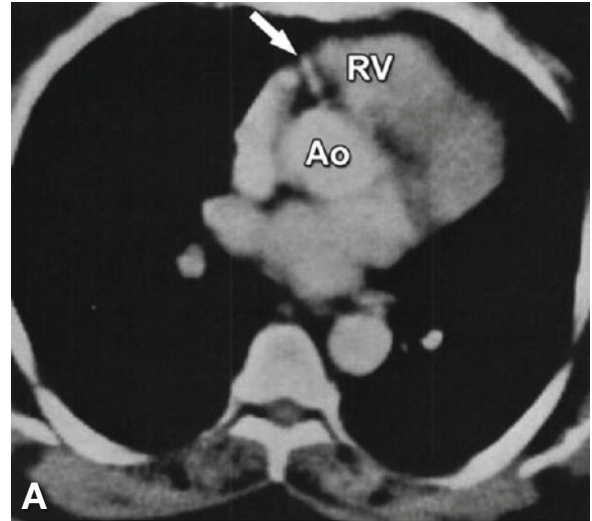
First images of coronary CTA. (Panel A) shows the proximal right coronary artery (*arrow*) and (Panel B) the left main (*arrow*) and left anterior descending coronary artery in another patient (*arrowhead*). Ao aorta, RV right ventricle (With permission from Guthaner et al. *AJR* 1979 (American Roentgen Ray Society))
